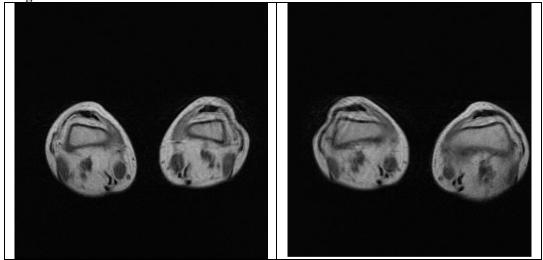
Coronal T1-weighted MRI revealing advanced muscle atrophy and fat replacement in the lower limbs.
